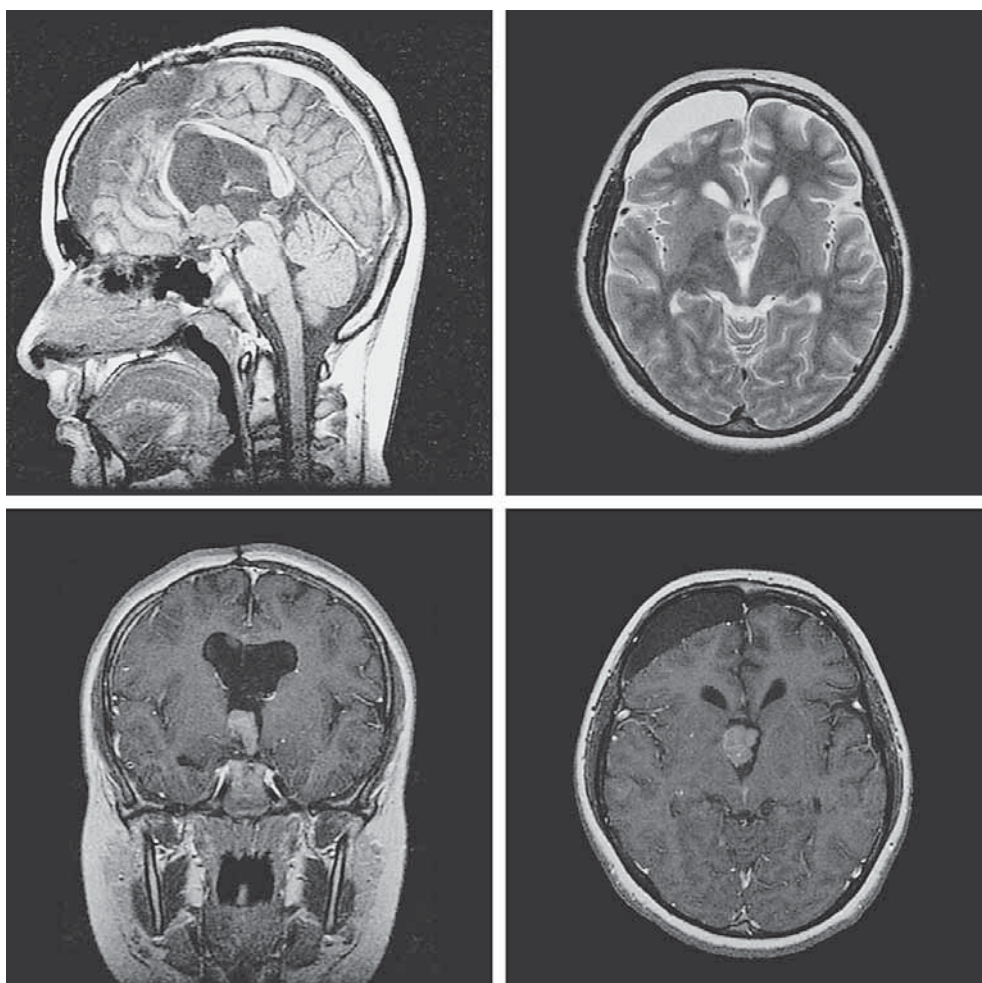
MRI acquired 22 months after the surgery showing tumor recurrence situated in the third ventricle.
